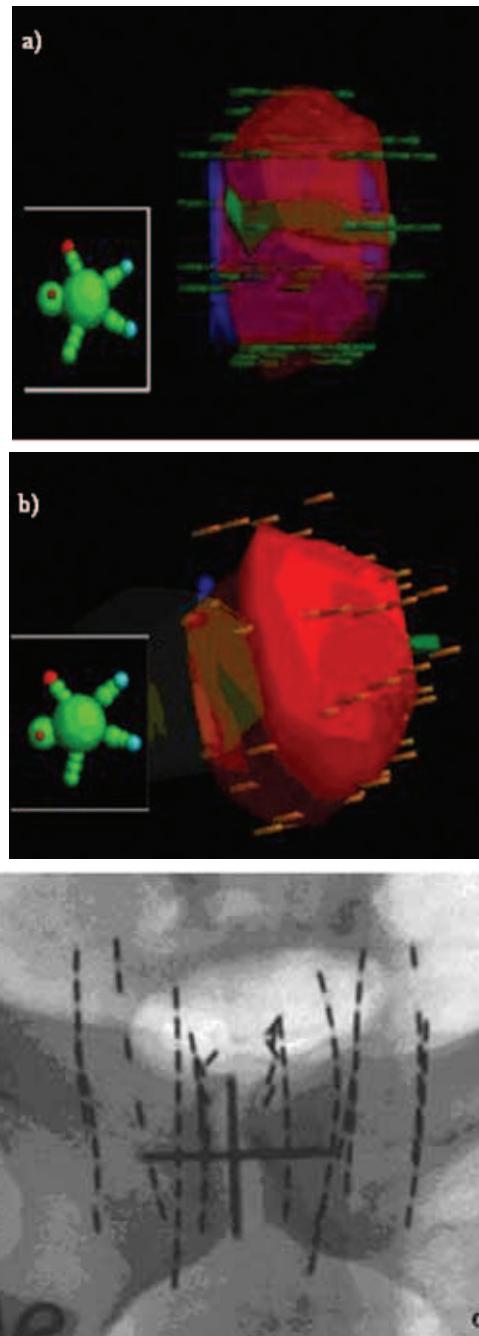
3D view of Pre implant Volume study and post implant CT. Indicating a well planned uniform distribution of sources in volume study (a) and post implant study (b), while using an implant with stranded sources (c).
